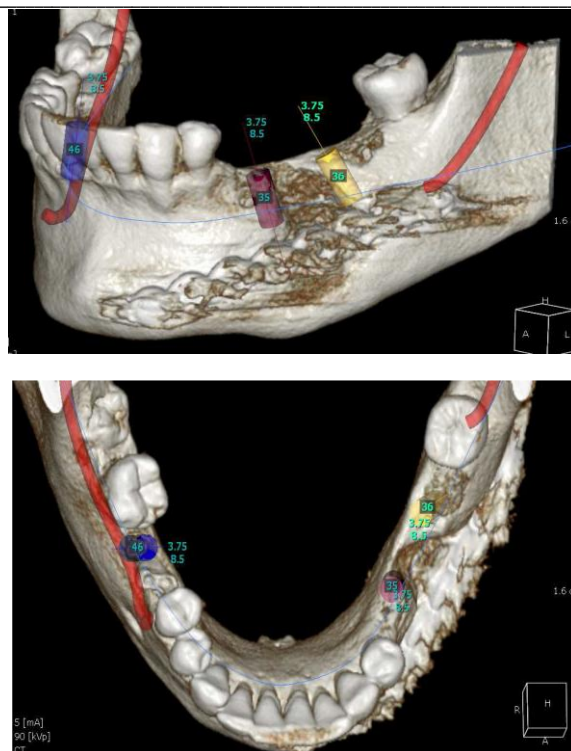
Six month post operative CBCT
